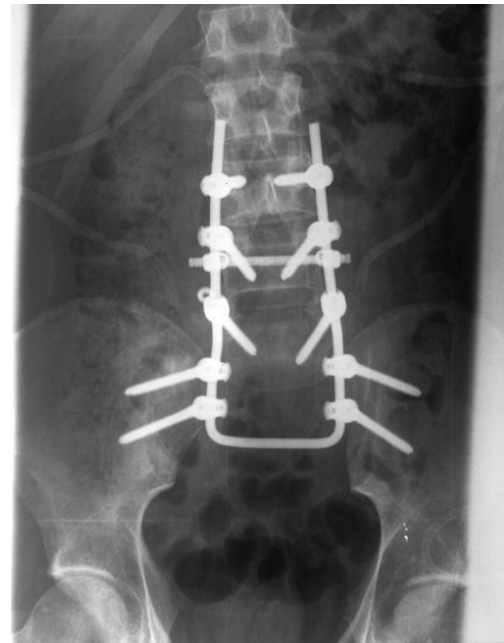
Postoperative X-ray of the patient after lumbo-pelvio fixation
